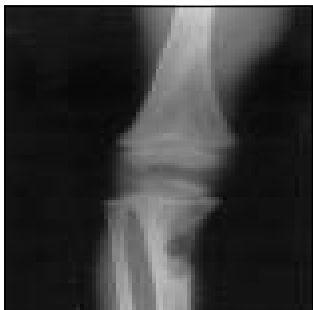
Anteroposterior x-ray view of the right leg showing metaphyseal cortical defect in upper tibia surrounded by an intense sclerotic reaction. A second oval lytic bone lesion is also seen in lower femur. The radiological features are consistent with non-ossifying fibroma.
